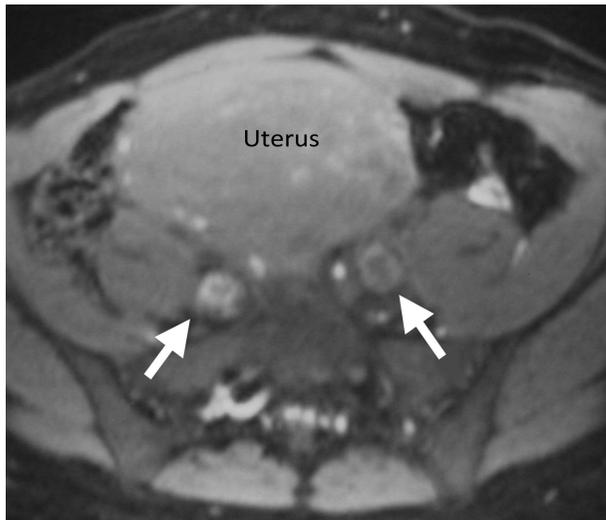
Pelvic magnetic resonance imaging showing bilateral common iliac venous thrombosis (arrows) caused by compression of an enlarged uterus (leiomyomas). Courtesy of Joseph M. Stavas, MD, Division of Interventional Radiology, University of North Carolina.
